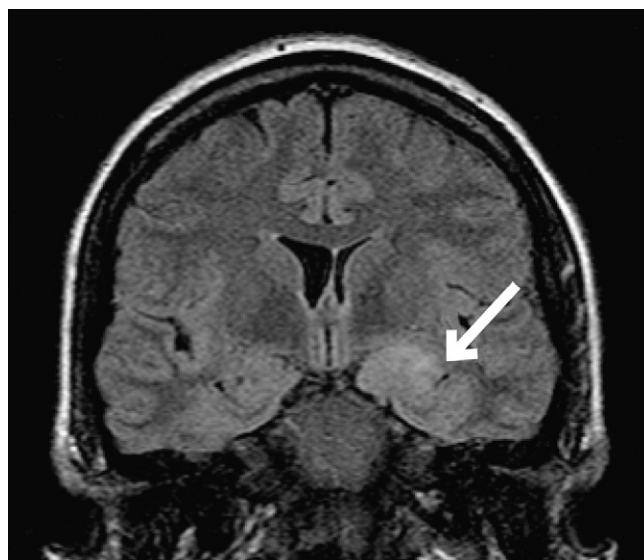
Coronal fluid-attenuated inversion recovery MRI showing a swollen and hyperintense left amygdala without significant contrast enhancement (arrow).
